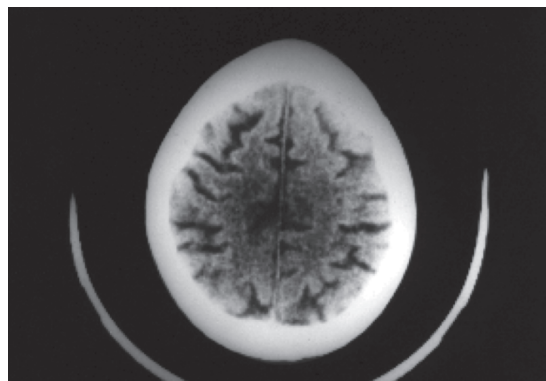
CT scan in Alzheimer's disease showing cortical atrophy, prominent sulci and gyri and ventricular dilatation
